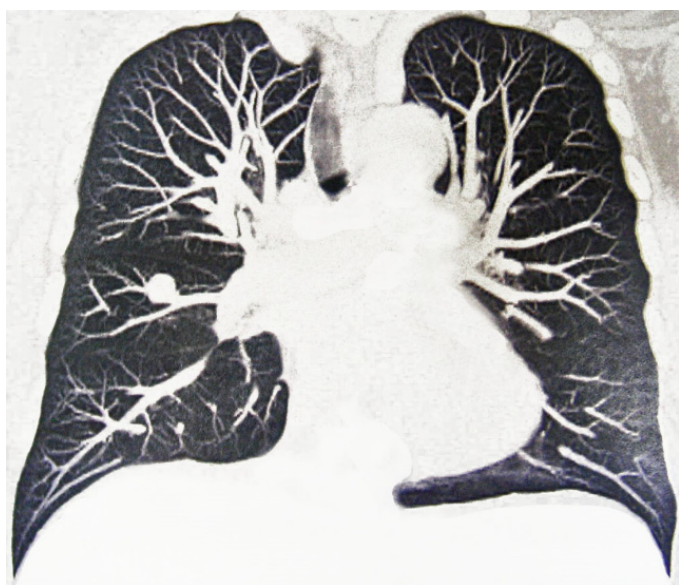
CT of the thorax (coronal reconstruction) suggesting that the pulmonary nodule might be a small PAA.
